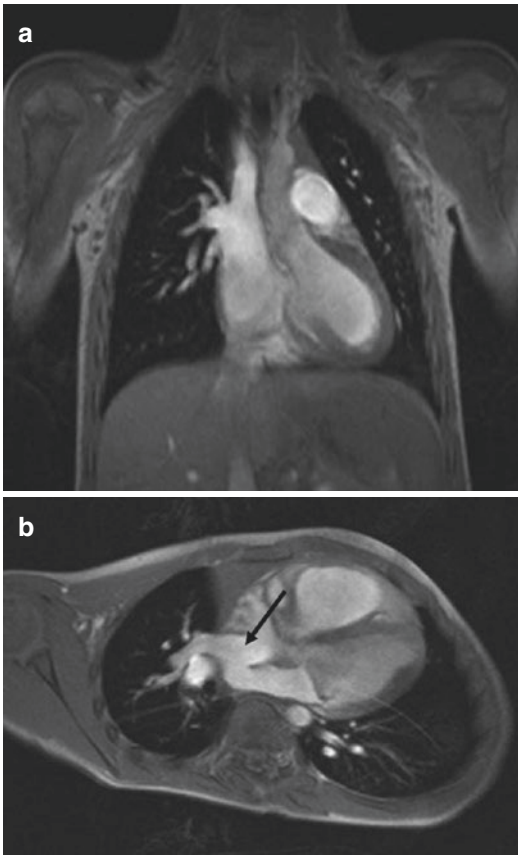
Right superior anomalous pulmonary venous return at MRI. (a) Coronal oblique view and (b) axial oblique view images obtained from cine FLASH MRI sequence demonstrate an anomalous drainage of right superior pulmonary vein through two veins into the right superior vena cava (RSVC) and a sinus venosus type of atrial septal defect (*black arrow*). The anomalous drainage involves the right superior and middle pulmonary lobes. Note the drainage into RSVC is below the azygos vein
